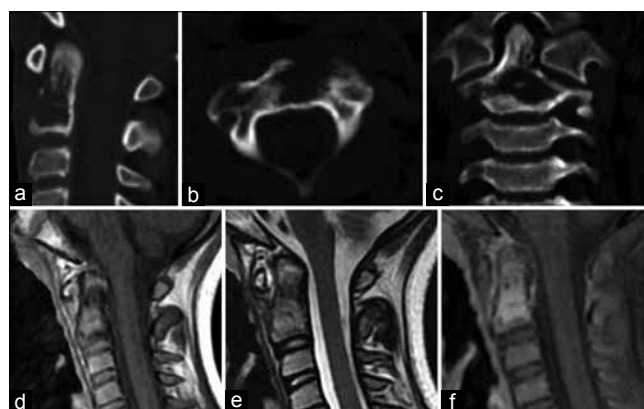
LCH of C2 in 9-year old female. Sagittal (a) reformatted computed tomography images scan revealed that lytic cone destruction in vertebrae of C2 with clear margin. Axial (b) reformatted computed tomography images scan revealed bone sclerosis around bone destruction. Coronal (c) reformatted images showed that anterior bone cortex was incomplete and bone sclerosis was seen around the bone destruction. Sagittal T1-weighted (d) images showed that C2 lesion was isointensity. Sagittal T2-weighted (e) images showed that C2 lesion was isointensity. On sagittal (f) gadolinium-enhanced T1-weighted image showed the moderate enhancement of C2 lesion
